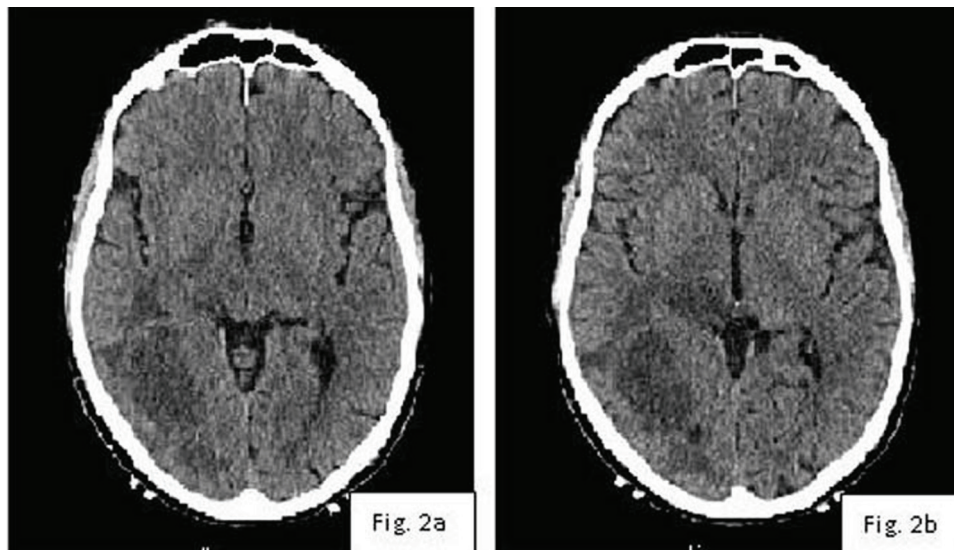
CT of the head postbiopsy.
